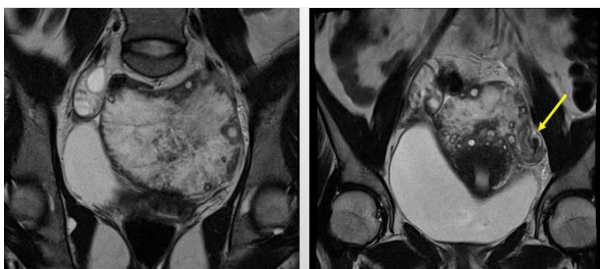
A 18 year old patient presented with acute abdomen since 2 hours followed by nausea and vomiting. MRI demonstrates, an enlarged left ovary, with hypointense stroma on T2W images with multiple peripherally displaced follicles. Also e/o hypointense twisted vascular pedicle (arrow) seen. Right ovary appears normal. - Ovarian Torsion
